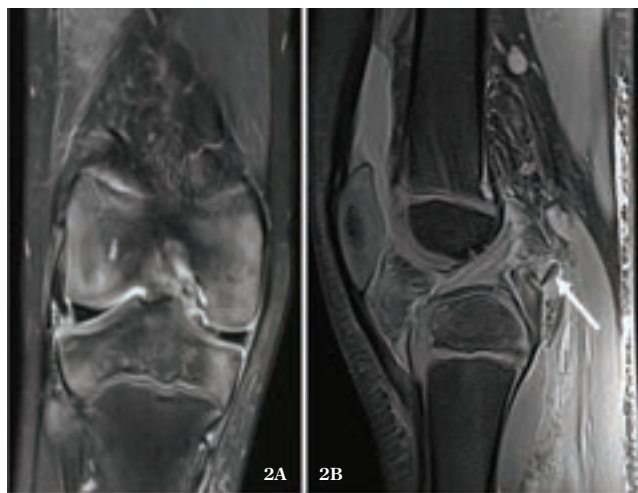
to 2B. MRI coronal view (2A) and sagittal view (2B) demonstrating a PCL avulsion of the distal femur attachment.
